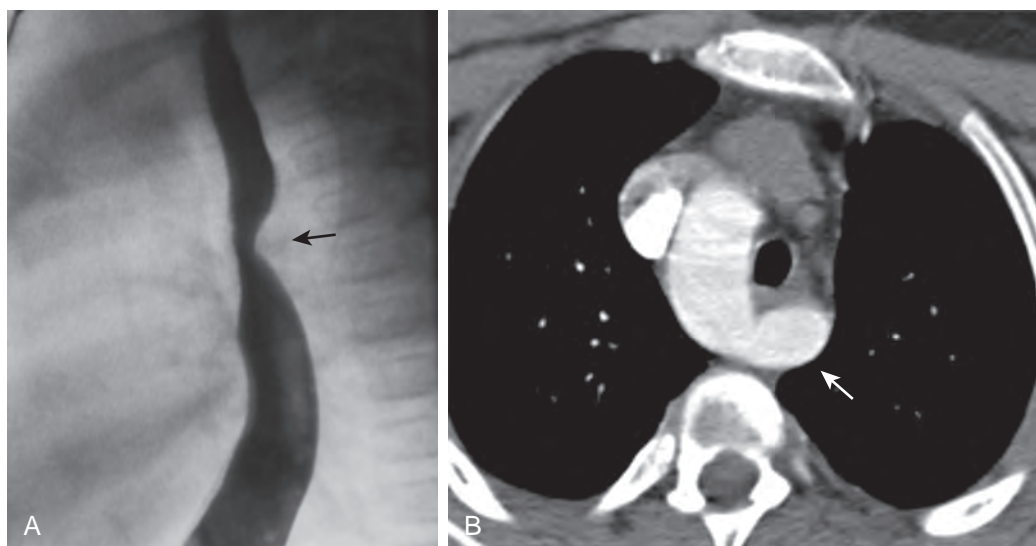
Right aortic arch with aberrant left subclavian artery. A. Lateral view of esophagus shows pronounced posterior impression on the esophagus by the aberrant vessel (arrow). B. Contrast-enhanced CT shows the aberrant left subclavian artery (arrow) arising from the right aortic arch and coursing posterior to the collapsed esophagus.
